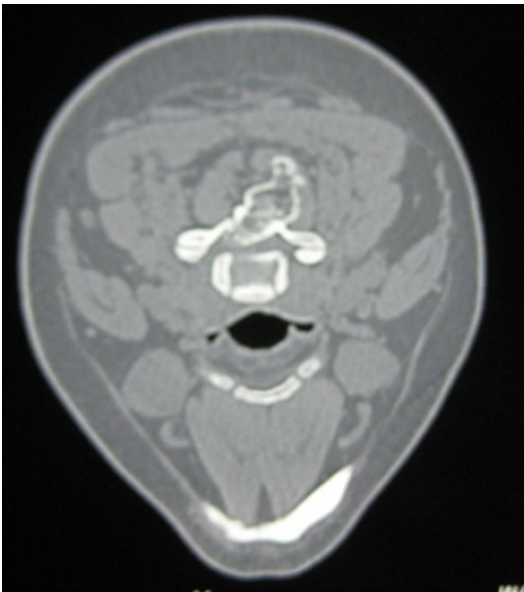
B.2.Osteochondromatosis with lesion in the cervical spine showing cord compression. CT scan
